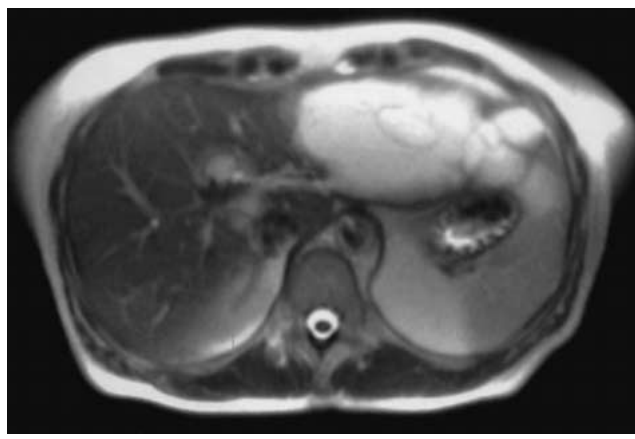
Computed tomography of a 37-year-old female suffering from right upper quadrant abdominal pain from a 7-cm liver tumor deeply sited in segment II of the liver requiring left lateral segmentectomy. The procedure was converted to an open approach due to the close contact of the tumor with the left hepatic vein. The postoperative course was uneventful, and the patient was discharged on postoperative day 7.
